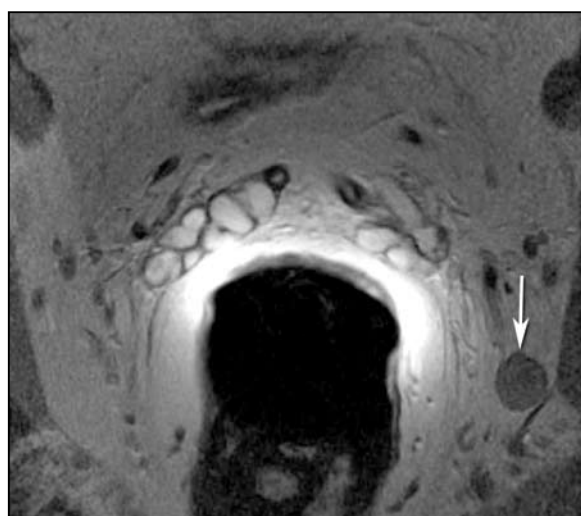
Axial T2 weighted image demonstrating an enlarged 12 mm left obturator lymph node. This showed restricted diffusion on DWI and ADC (not shown) raising suspicion for nodal metastasis.
